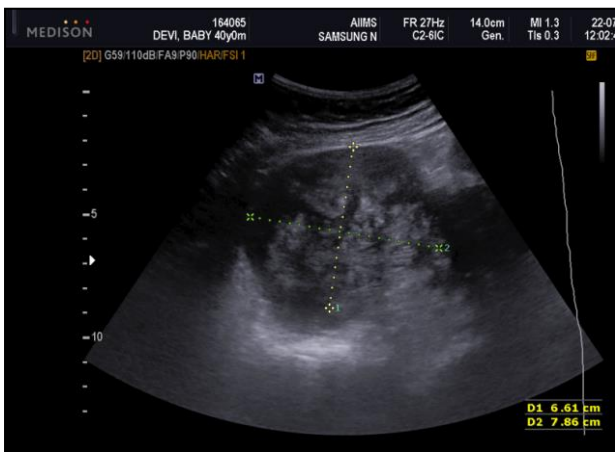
Solid cystic mass arising from right ovary in trans abdominal ultrasound.
